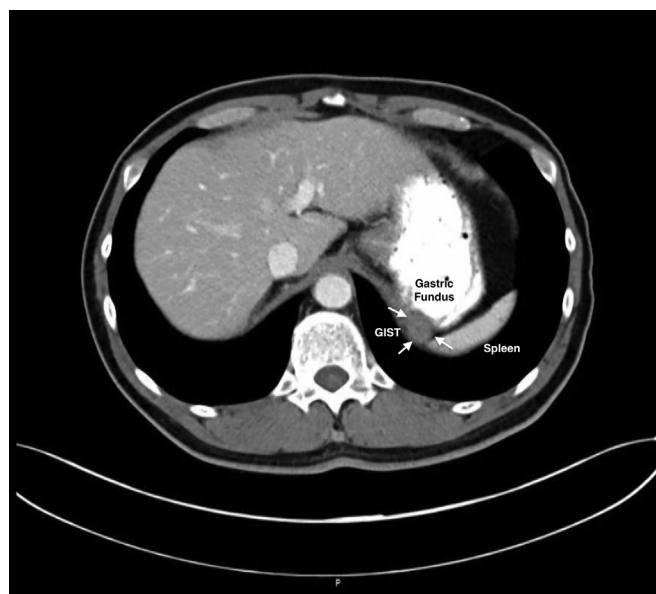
Abdominal CT showing 2.5-cm mural gastrointestinal stromal tumor (GIST) in the gastric fundus (arrows); approximately 2/3 of the tumor is extraluminal, abutting the spleen.
